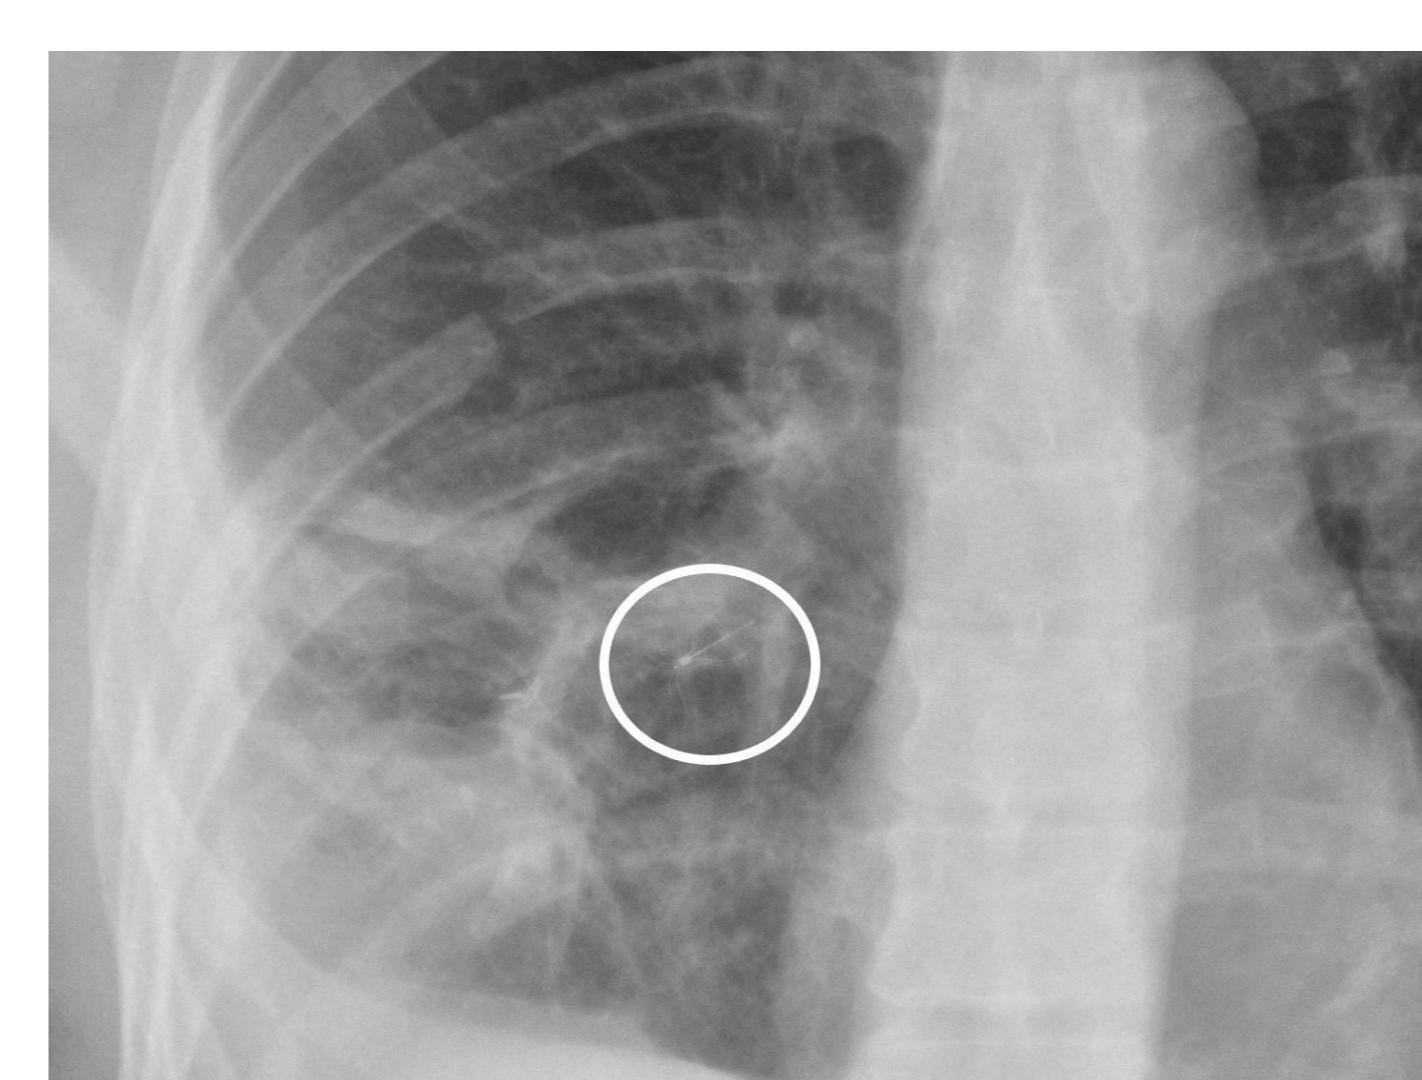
Chest Xray showing EBV (Spiration, size 9mm) deployed in RB9
